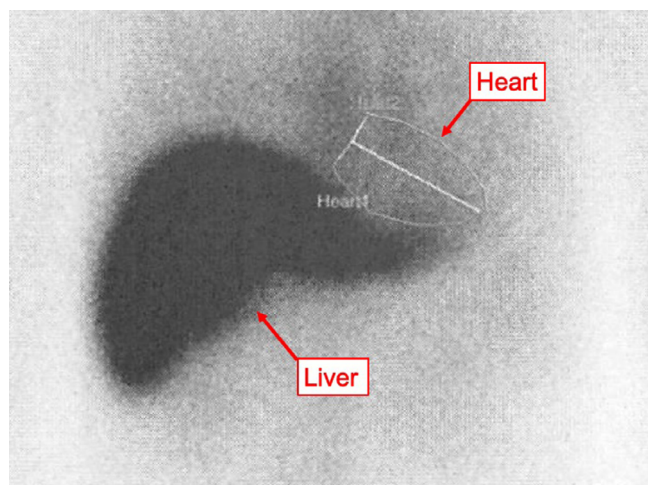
^{123}I - β -methyl-P-iodophenyl-pentadecanoic acid scintigram showing absence of myocardial ^{123}I - β -methyl-P-iodophenyl-pentadecanoic acid uptake despite normal hepatic accumulation.
